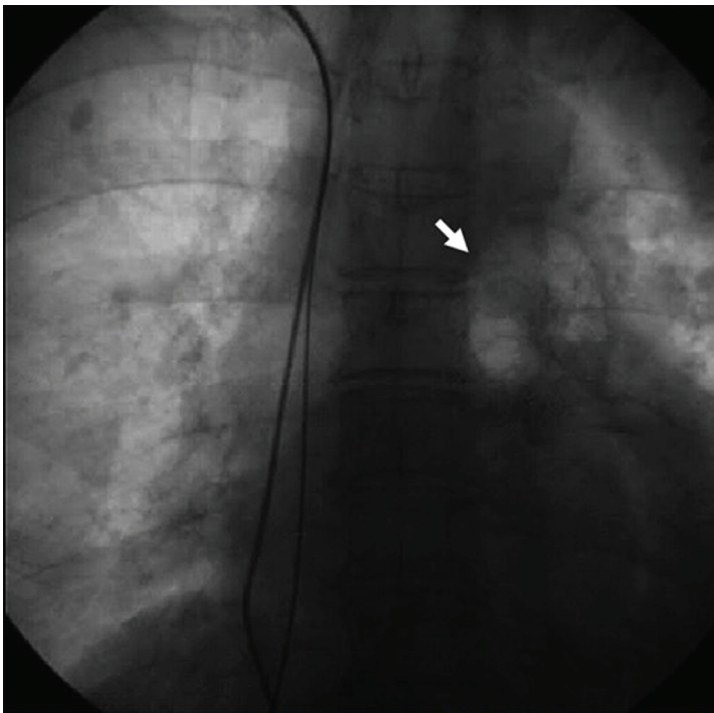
Chest X-ray showing a large air embolus (arrow) in the main pulmonary artery bifurcation during permanent pacemaker implantation.
